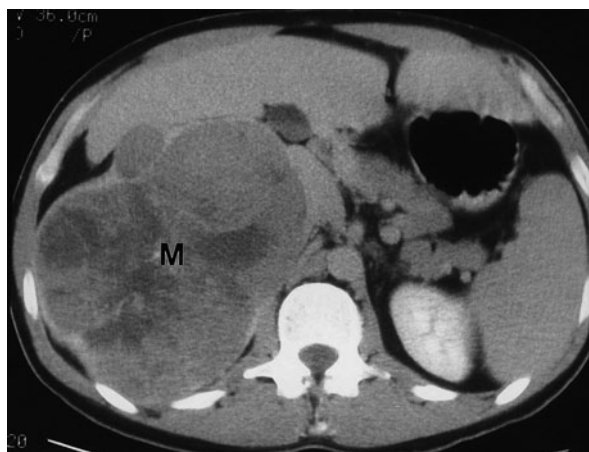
Adrenal carcinoma causing Cushing's syndrome. Computed tomography (CT) scan shows a huge, inhomogeneous, right adrenal mass (M). (Reprinted with permission from [59])
